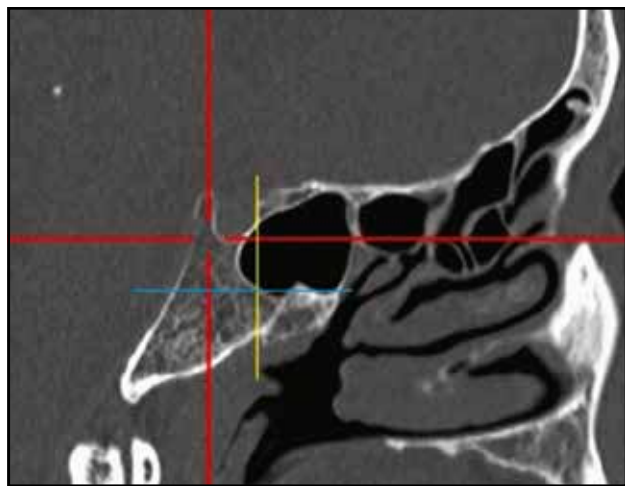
Subdorsal extension (cranio-facial CT scan, sagittal slice; blue horizontal line - the vidian canal, vertical yellow line - along the posterior wall of the sella).
